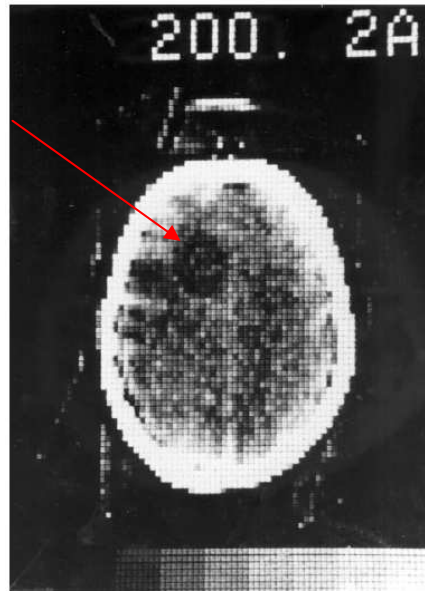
The first clinical CT scan, performed at Atkinson Morley's Hospital on October 1st 1971. Red arrow indicating left frontal lobe tumor. Reproduced from [2].
